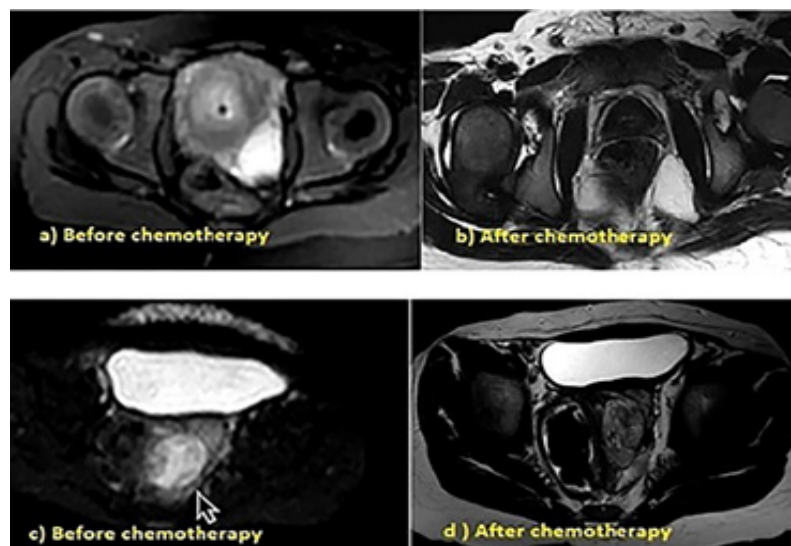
MR images of case 1 before (a) and after chemotherapy (b), MR images of case 2 before (c) and after chemotherapy (d)
